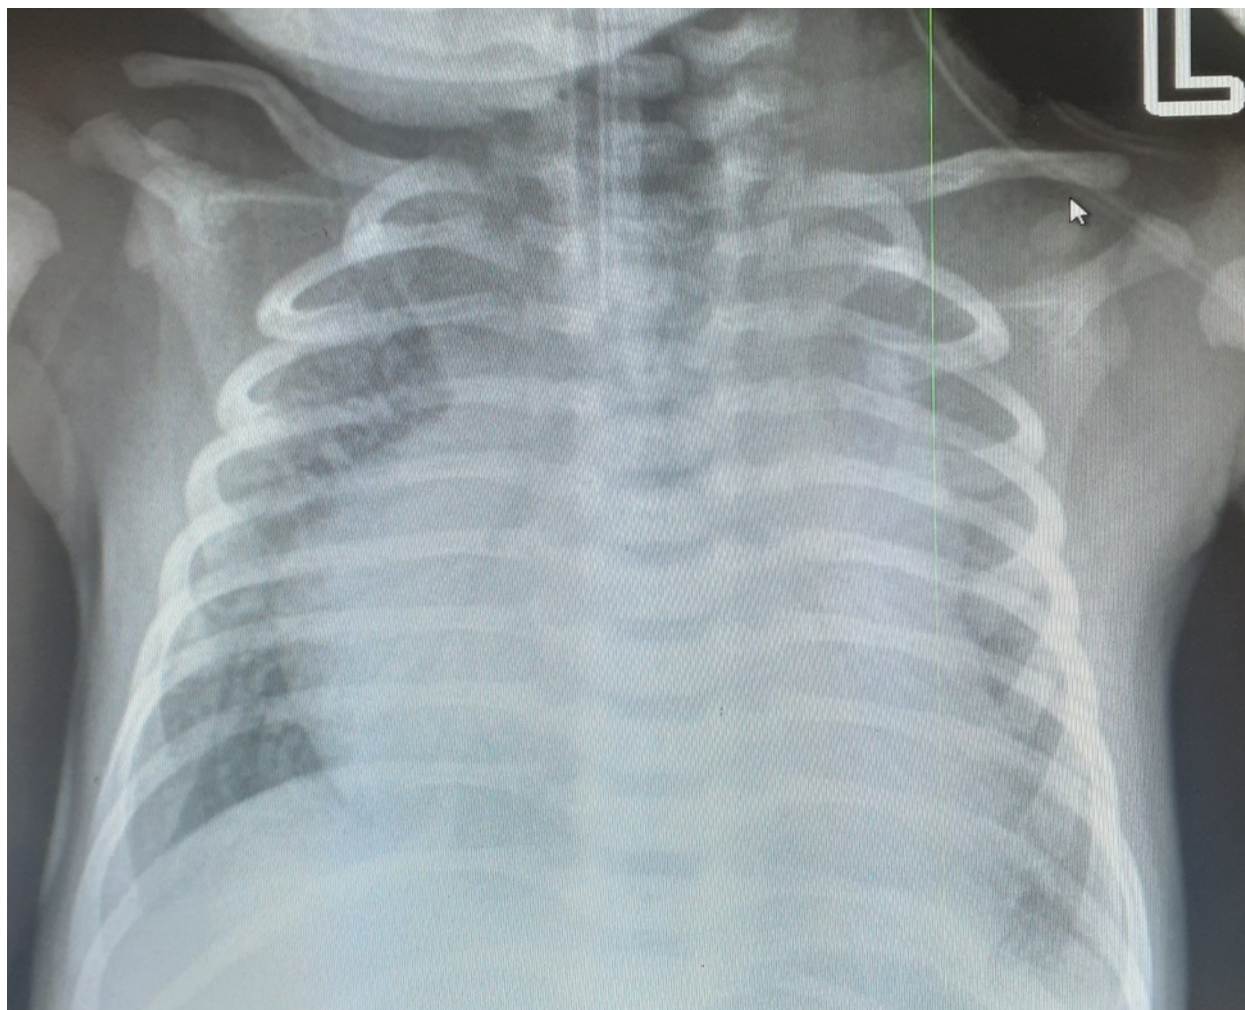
Chest x-ray of the infant taken on the 11th day of life showing cardiomegaly
